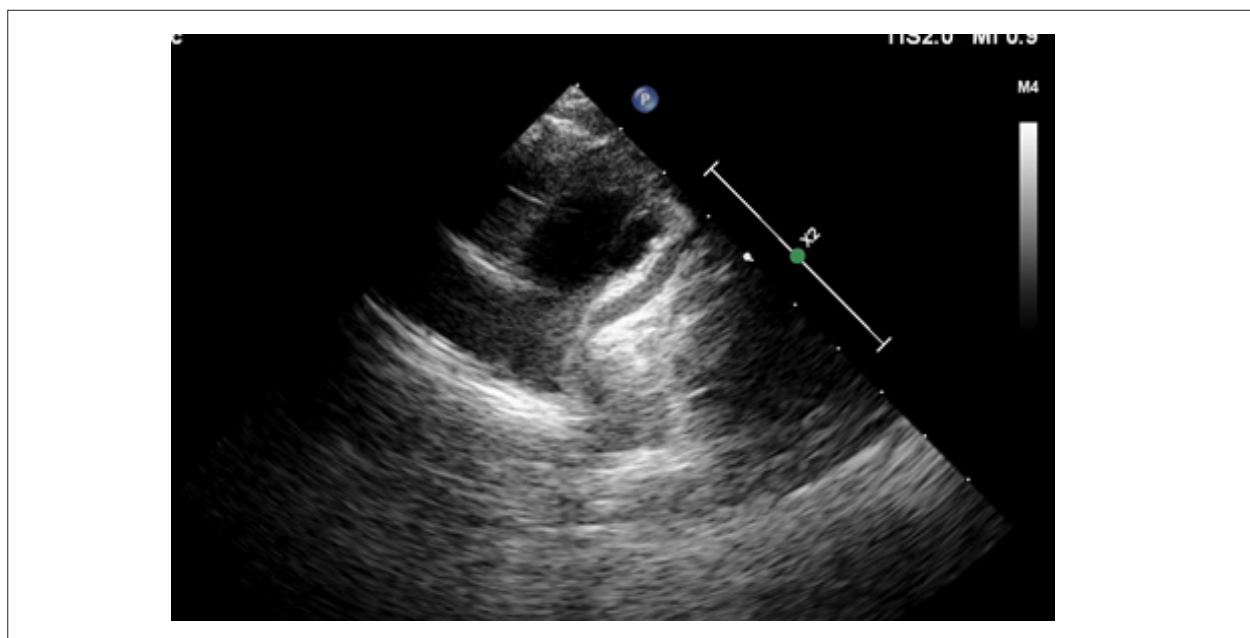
Transsthoracic echocardiography demonstrated an apparent ectasia (3.5 mm; z score 5.58) in the left anterior descending coronary artery.
